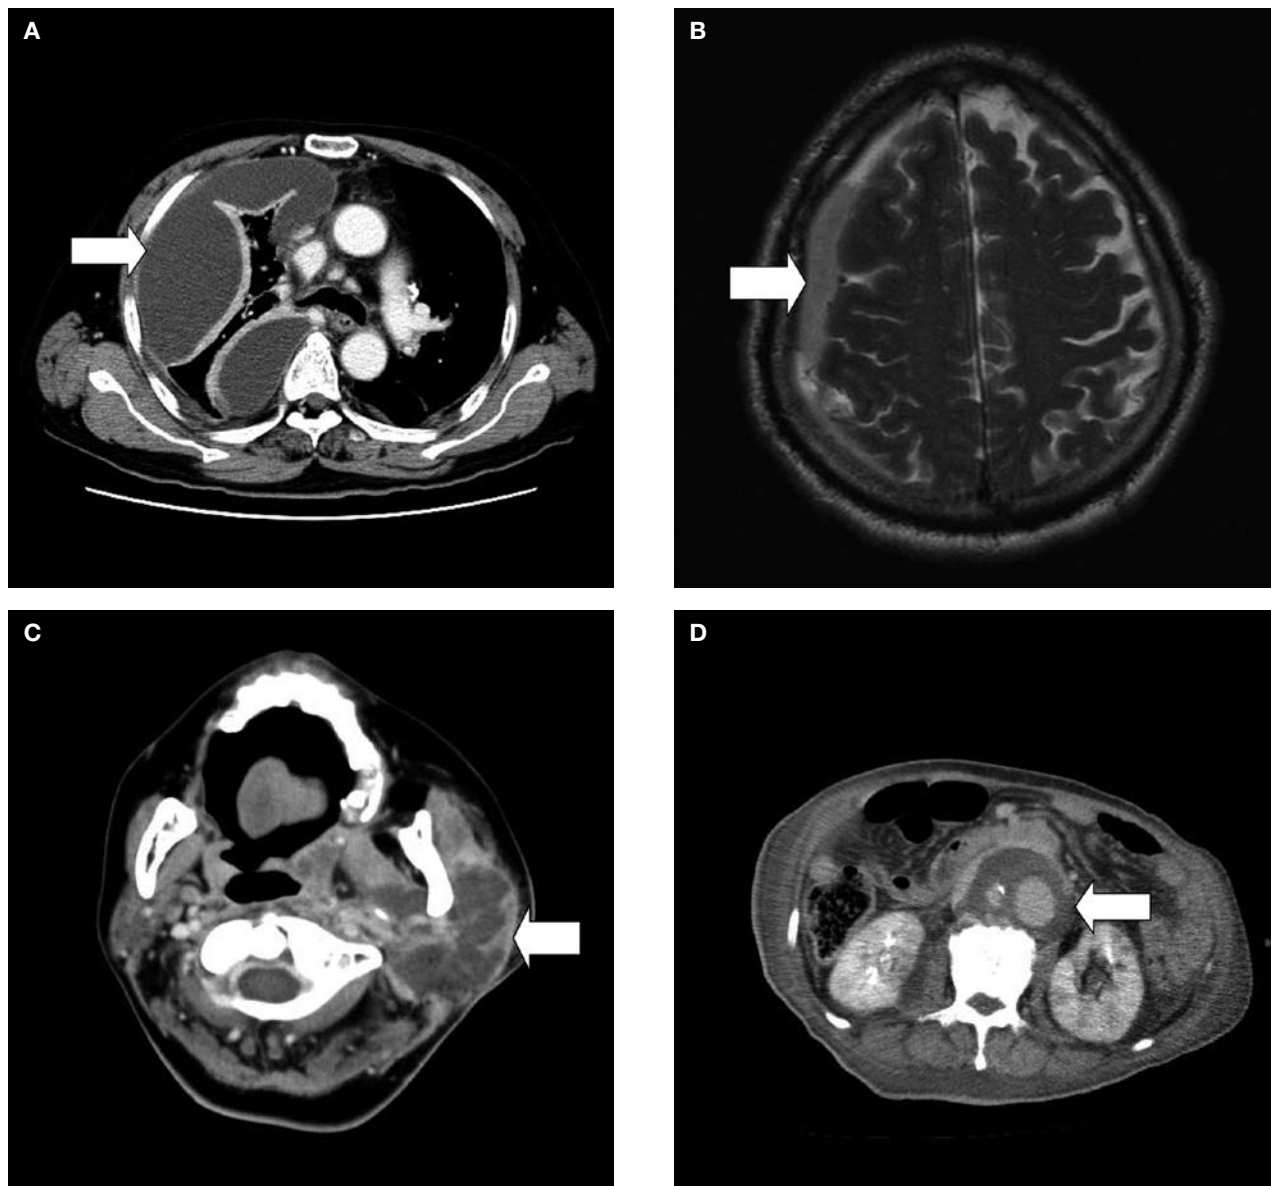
Radiographic images of several cases of primary *Klebsiella pneumoniae* extrahepatic purulent infections (white arrow). (A) Computed tomography: thoracic empyema, right. (B) Brain magnetic resonance imaging (T2I): subdural empyema, right. (C) Computed tomography: parotid abscess, left. (D) Computed tomography: mycotic aneurysm of infrarenal aorta.
